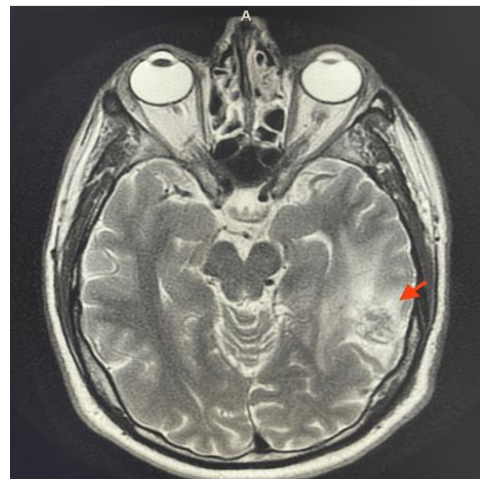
MRI with contrast conducted during hospitalization revealing post-radiation AVM status in the left temporal lobe, including perilesional edema and mass effect (red arrow).
